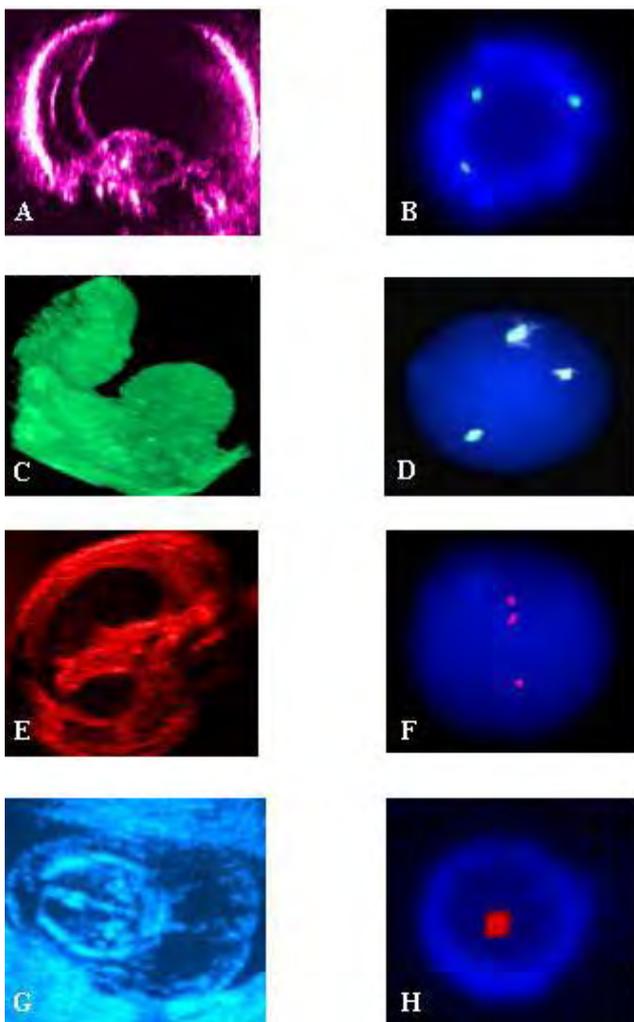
Ultrasongraphic and Amnio-FISH features of fetuses with chromosomal aneuploidies. (A) Holoprosencephaly in Trisomy 13. (B) Amnio-FISH showed 3 copies of chromosome 13. (C) Exomphalos in Trisomy 18. (D) Amnio-FISH revealed 3 copies of chromosome 18. (E) Double bubble sign characteristic of duodenal atresia in Trisomy 21. (F) Amnio-FISH showed 3 copies of chromosome 21. (G) Cystic hygroma is a characteristic feature of Turner's syndrome (XO). (H) Amnio-FISH showed a single copy of chromosome X.
